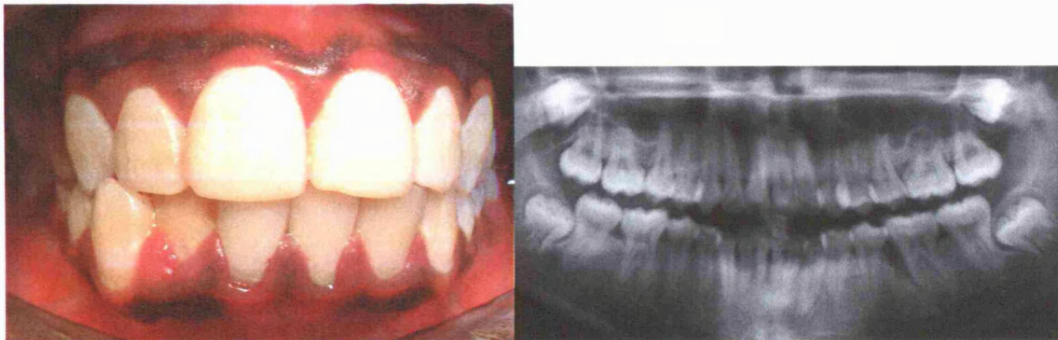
Frontal intraoral picture and orthopantomograph of the 15-year old Black- Caribbean female patient, sister of the patient shown in figure 8.1. Localised vertical bone defects are present around 26 (UL6) and 36 (LL6). A diagnosis of LAgP was made.
